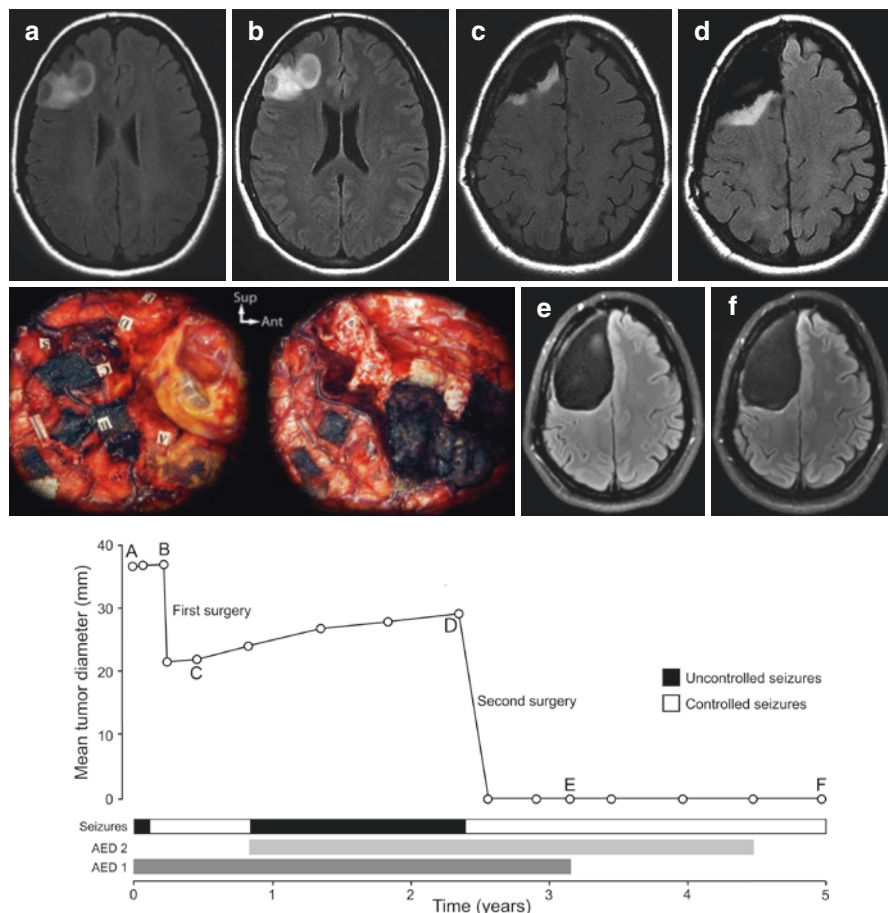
Example of the epileptic seizure history along the natural course of a diffuse low-grade glioma. The evolution of the radiographic mean tumor diameter is plotted over time. A 33-year-old right-handed female patient presented with partial motor and secondary generalized epileptic seizures controlled with one anti-epileptic drug and a right frontal non-enhanced mass with spontaneous growth on MRI (velocity of diametric expansion at 2.6 mm/year). A subtotal resection was performed under general anaesthesia and confirmed the diagnosis of a World Health Organization grade II oligodendroglioma. 5 months after surgery, epileptic seizures recurred, requiring the introduction of anti-epileptic drug 2 and the residual tumor grew on MRI (velocity of diametric expansion at 3.8 mm/year). Epileptic seizures remained uncontrolled. A second surgical resection was performed using intraoperative functional mapping with direct cortical and subcortical electrostimulations under awake condition and allowed a supratotal resection beyond MRI-defined abnormalities (see intraoperative photographs before and after resection; each numbered tag represents an eloquent site at the cortical and subcortical levels). Following this second surgery, epileptic seizures were controlled, anti-epileptic drug 1 was stopped at 6 postoperative months and anti-epileptic drug 2 was reduced at 24 postoperative months. At last follow-up, the patient was seizure free and no glioma recurrence was observed.
